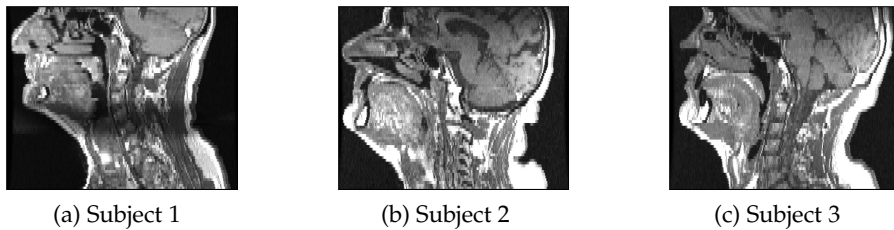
Three T1-weighted MR images obtained from three different subjects. The lack of spatial correspondence between the images is due to the differences in morphology and in posture of the three subjects.
